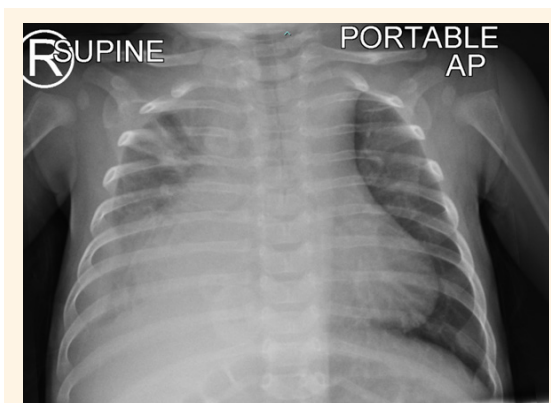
Initial chest x-ray of a two-month-old male infant showing air space opacities in the right lung with silhouetting the cardiac border and the right hemidiaphragm. The right costophrenic angle is obliterated.
